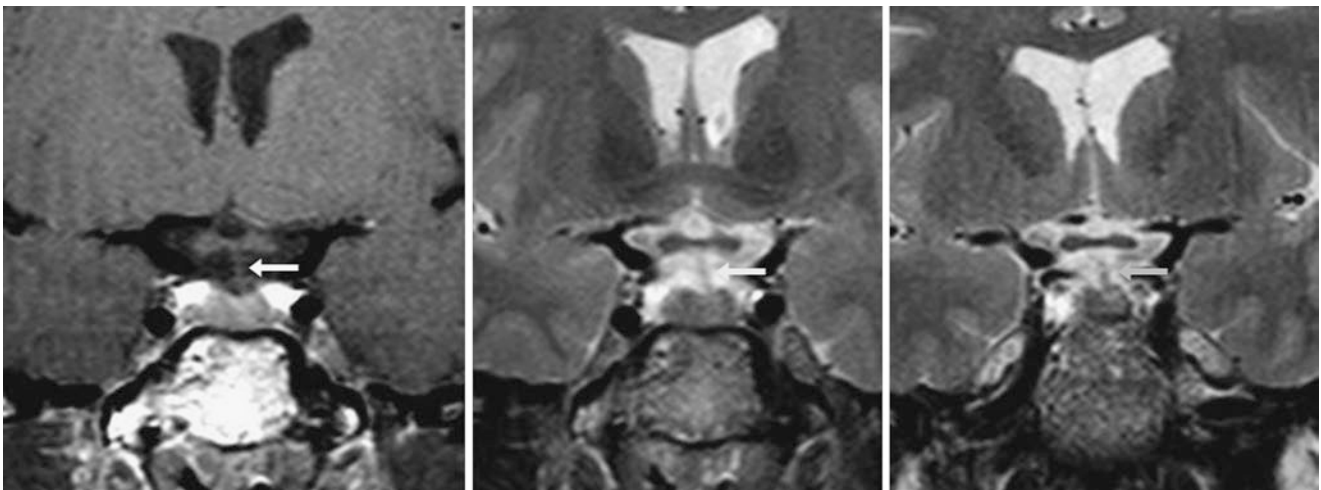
The patient was a 34-year-old female with visual symptoms (thought related to demyelinating disease) with a 3 T MRI that demonstrated normal mild infundibular shift to the left (*arrows*). This was
